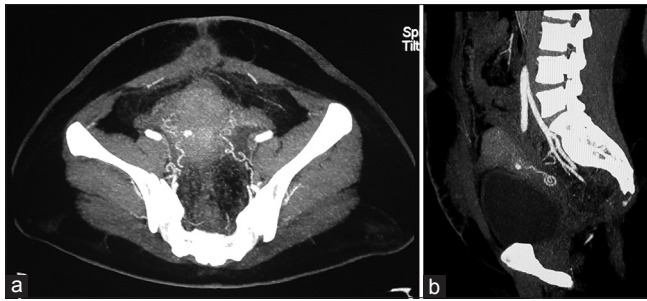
(a) Axial computed tomography maximum intensity projection image in case 3 showing small right uterine artery pseudoaneurysm near cervix, (b) sagittal reformatted maximum intensity projection image showing the tortuous right uterine artery along with well-opacified pseudoaneurysm
